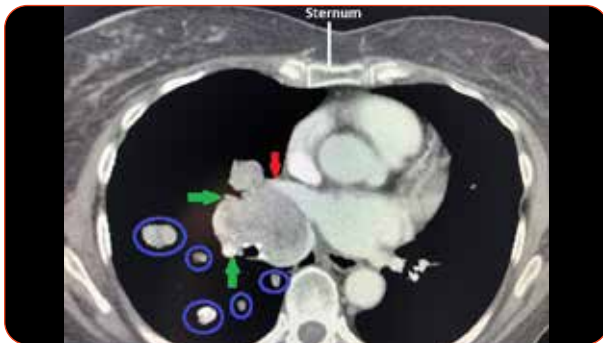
Enhanced axial CT scan showing (i) small secondary deposits (blue circles) in the right lung from a RCC, and (ii) large right hilar lymph node (green arrows) compressing right superior pulmonary vein (red arrow).
